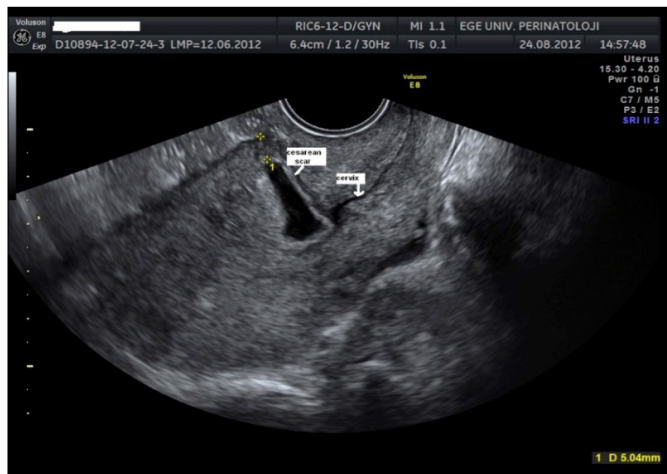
Transvaginal ultrasound image of the cesarean scar pregnancy. Gestational sac in the lower anterior wall of the uterus. Between two yellow pointer indicates scar defect Wall
